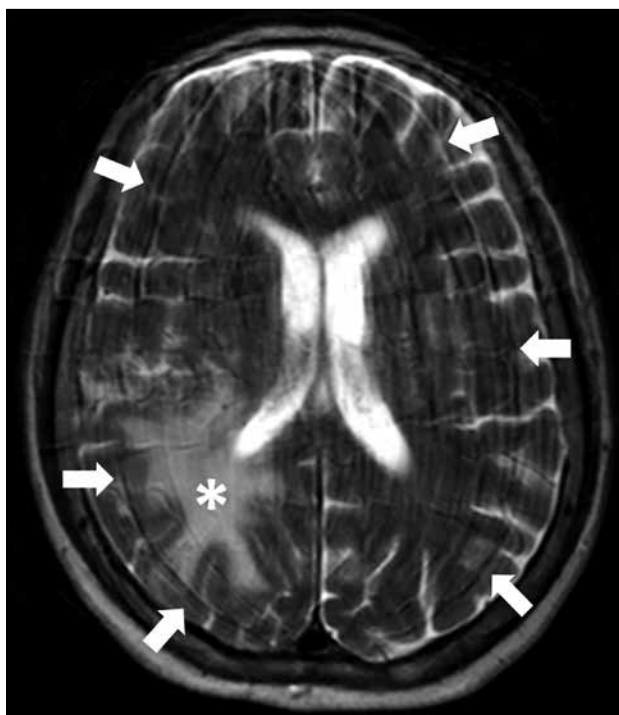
Axial T2-weighted image of the brain showing significant truncation artifact (white arrows) along the high-contrast brain-fluid interface, obscuring the normal anatomy. This patient has significant vasogenic oedema at the right frontal and parietal white matter (white asterisk) due to underlying brain metastasis.
